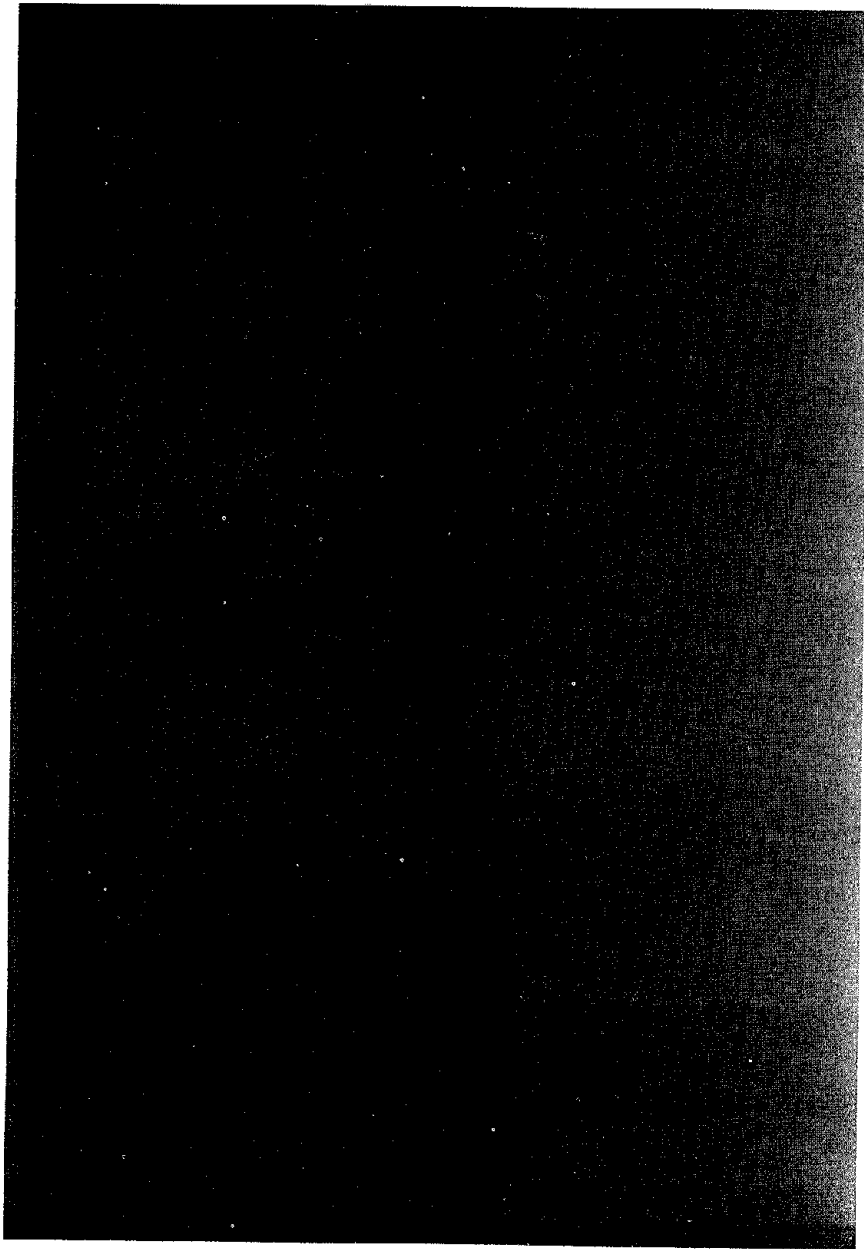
Radiograph chest test object where all steps cannot be visualized.
